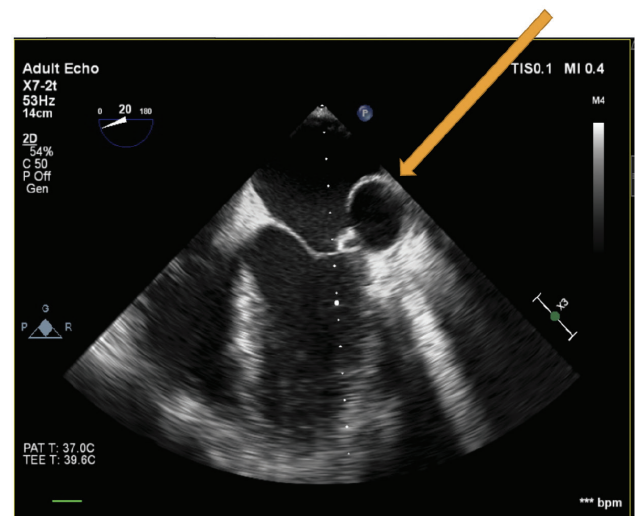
Trans-esophageal echocardiography appearance of intracardiac cysts in the left atrium
